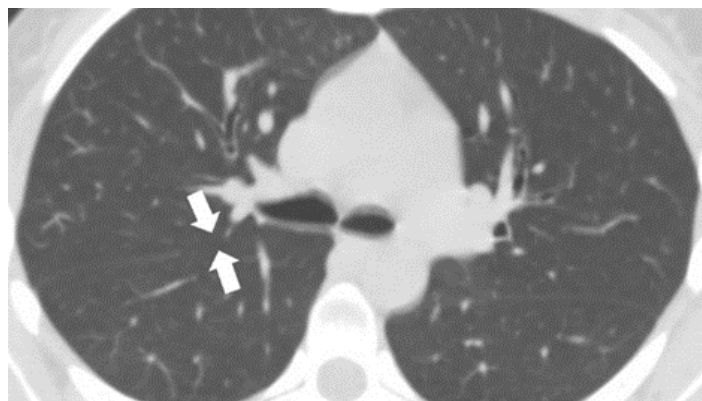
Thorax computed tomography image in the axial section showing an incomplete oblique fissure (arrows) in the right lung.
